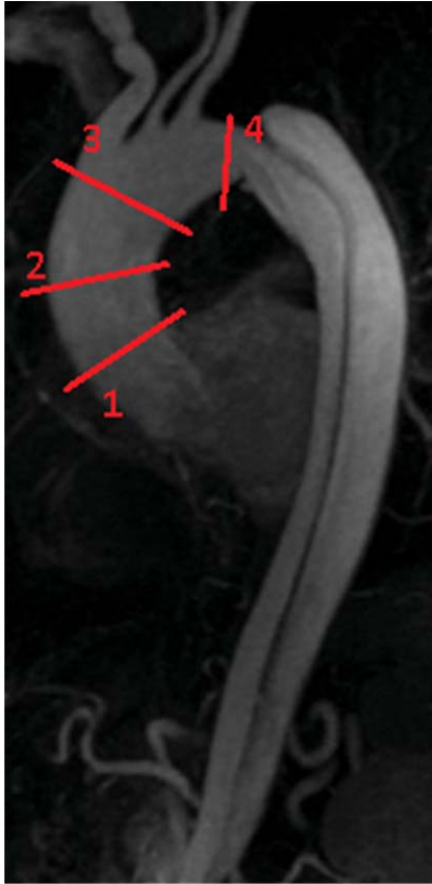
Longitudinal scan of the aorta with highlighted in red the cross-sections in which PC-MRI has been acquired
